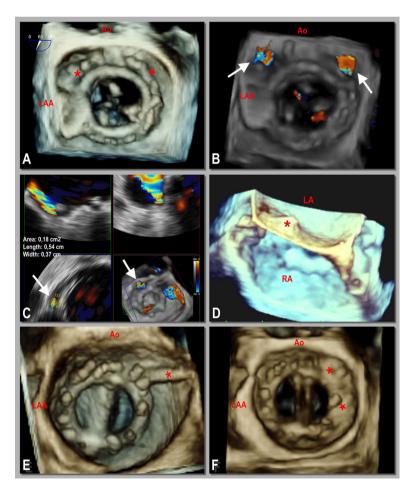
Echocardiographic evaluation of a mitral PVL. A: 3D-TEE imaging of a prosthestic mitral valve in the surgical position with asterisks identifying two PVLs. B: 3D-TEE colour doppler imaging of the same patient with arrows identifying two jets of mitral PVR (11:00 h and 2:00 h). C: Sizing of a mitral PVL by 3D-TEE using the QLAB software (Philips Medical). D: 3D-TEE imaging during the transseptal puncture. 'Tenting' of the atrial septum can be seen (red asterisk). E: Guidewire across the mitral PVL (red asterisk). F: AVP-III devices deployed (red asterisk). LAA, left atrial appendage; Ao, Aortic valve. RA, right atrium; LA, left atrium.
